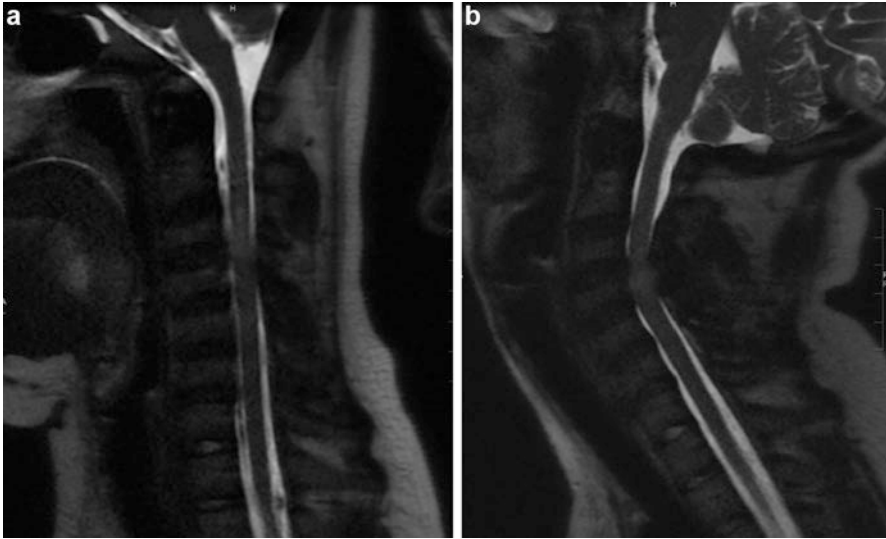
MRI T2 sequence dynamic sagittal images of the spine demonstrate progressive spinal canal narrowing at C3–C4 in neck extension compared to neutral flexion position, related to combination of progressive disc bulge and ligamentum flavum buckling
